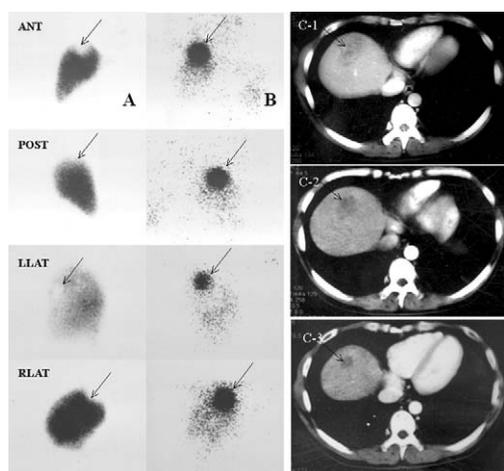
Immunoscintigraphy and computed tomography scans of hepatocellular carcinoma (HCC) in the right hepatic lobe of a patient. (A) Defect in the upper region of the right lobe of the liver (arrow) in  $^{99\text{m}}\text{Tc}$ -sodium phytate-colloid scan. (B) Hot region of HCC (arrow) in SPECT 7 days after treatment. (C) CT scan results of the same patient: (C-1) pretreatment assessment ( $5.8 \times 4.5$  cm, arrow); (C-2) 1 month after the first administration ( $4.5 \times 3.5$  cm, arrow); (C-3) partial response ( $4 \times 3.2$  cm, arrow) 1 month after the second administration. ANT = anterior; POST = posterior; LLAT = left lateral; RLAT = right lateral.
